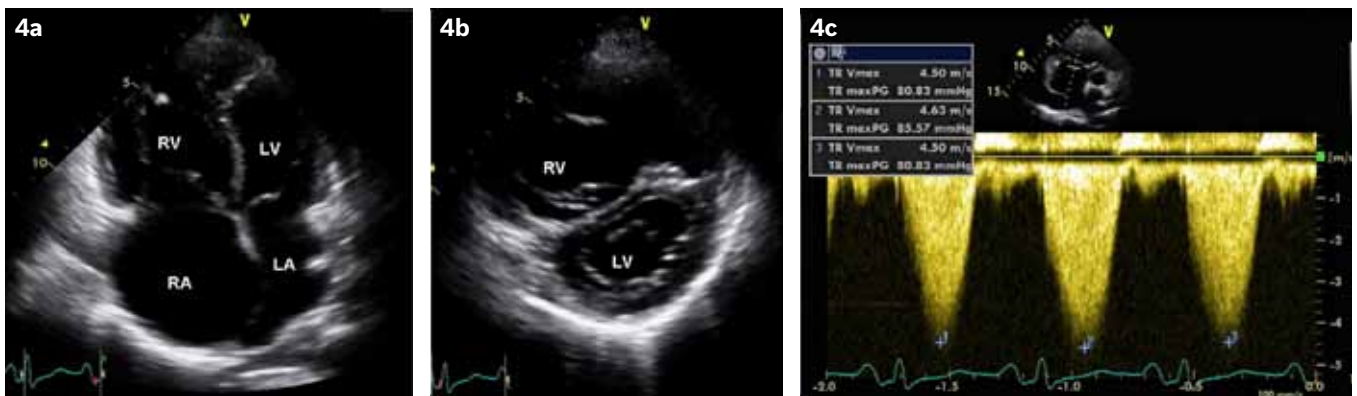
(a) Echocardiogram in the apical four-chamber view shows dilated right heart chambers; (b) Echocardiogram in the parasternal short axis shows a D-shaped left ventricle, reflecting high right ventricular pressures. (c) Continuous wave Doppler interrogation of the tricuspid regurgitant jet shows elevated right ventricular and pulmonary artery systolic pressures. RA: right atrium; RV: right ventricle; LV: left ventricle; LA: left atrium
